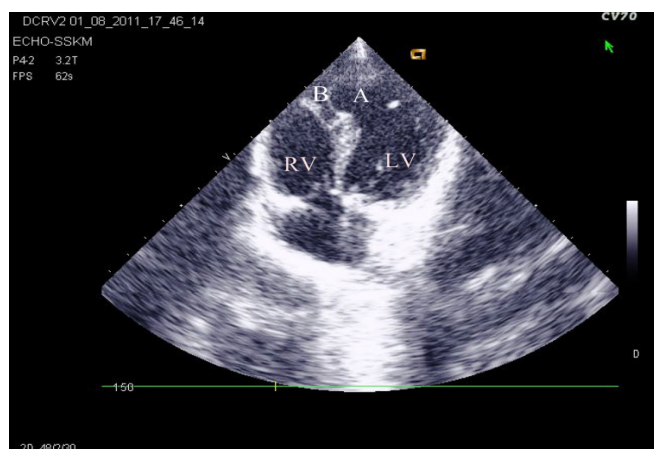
2 D echocardiography showing a large apical muscular Ventricular septal defect and an anomalous muscle band across RV apex.
